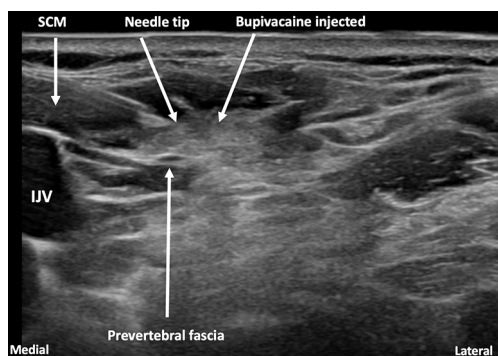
Ultrasound image of cervical plexus block injection to the right neck. The operator stands at the head end of patient, with ultrasound transducer placed at the midpoint of the neck between the clavicle and mandible. Note the 21 G needle tip approaching from medial to lateral, through the SCM, injecting 0.25% bupivacaine into the potential space between the SCM and prevertebral fascia. SCM, sternocleidomastoid muscle; IJV, internal jugular vein.
